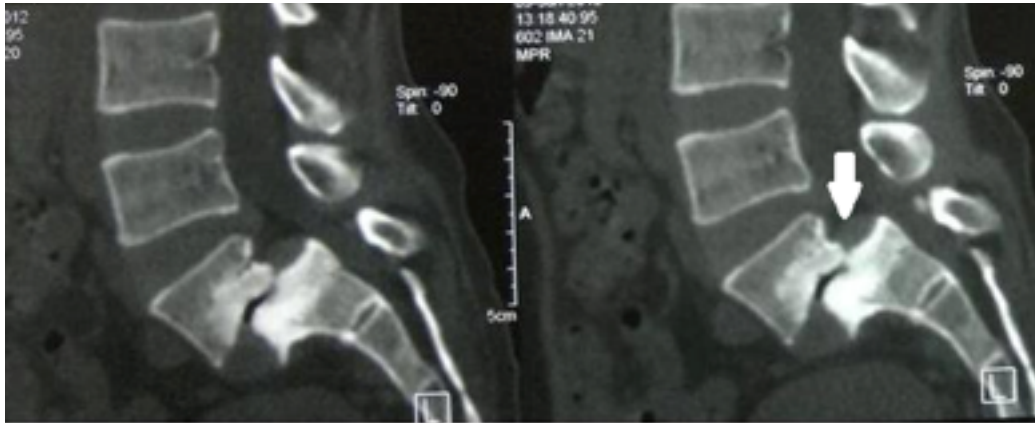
CT-Scan of lumbosacral spine (sagittal views) shows L5-S1 spondylolisthesis Meyerding grade II (arrow).
